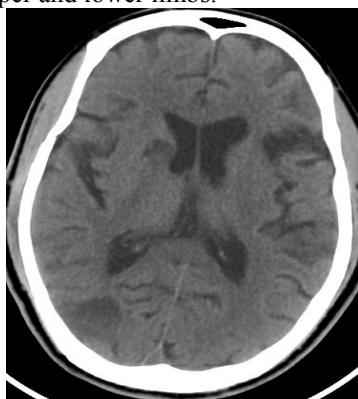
Plain axial CT of Infarct noted in the right corona radiata and occipital region
